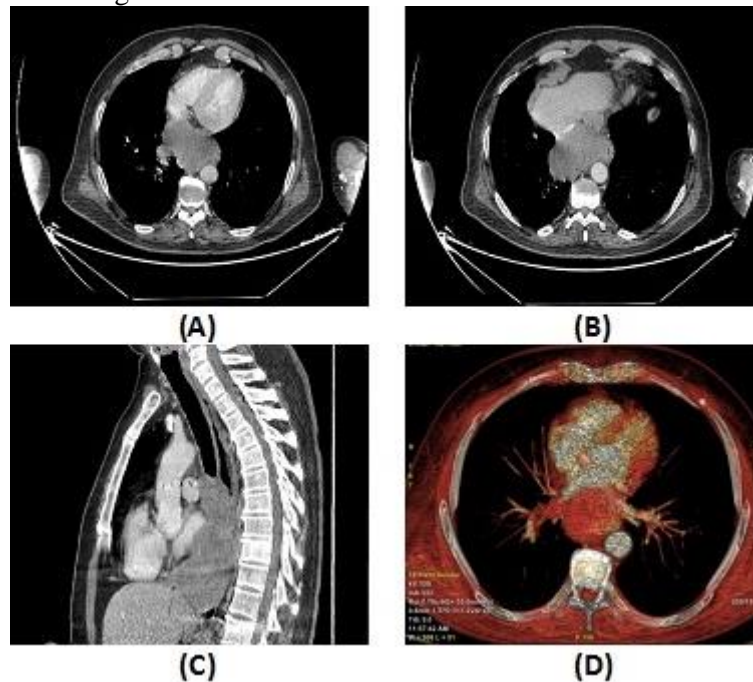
Esophageal carcinoma in a male patient aged 51 years old, condition started with dysphagia. (A, B) post IV and oral swallow contrast axial CT images show irregular well defined large irregular shaped enhanced soft tissue mass lesion. (C) sagittal reconstructed image showed extension of the mass lesion. (D) volume rendering technique image.
